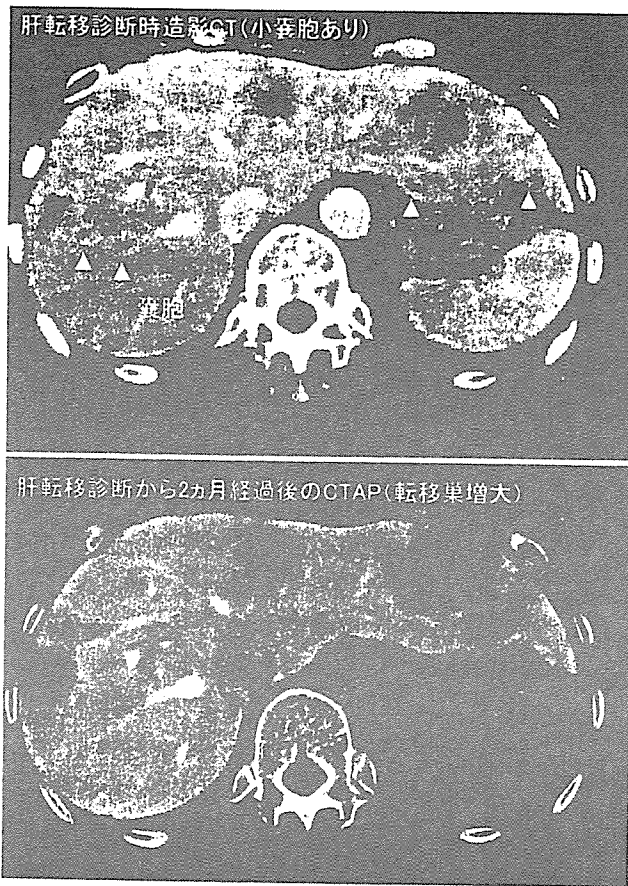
造影 CT (診断時) と CTAP (2ヵ月後)
